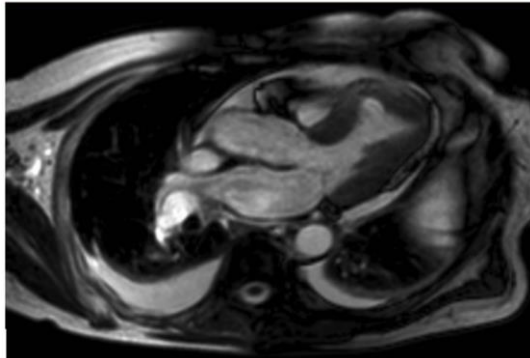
The aneurysm containing the rupture can be seen on the distal septum (MRI).
